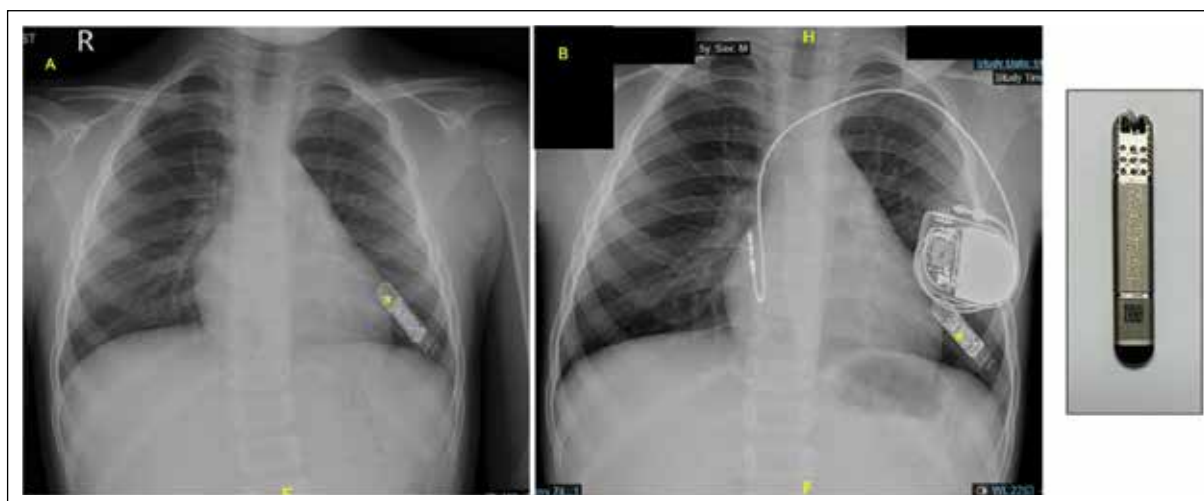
These frontal chest radiographs of a child with long QT syndrome presented with recurrent episodes of loss of consciousness; for the diagnosis of the event, an implantable loop recorder was inserted (yellow *). As the event recorder showed the bradycardia-induced torsades, this child received a single chamber atrial-based pacemaker. Later on, the recorder was explanted. The explanted device showed in the inset.
